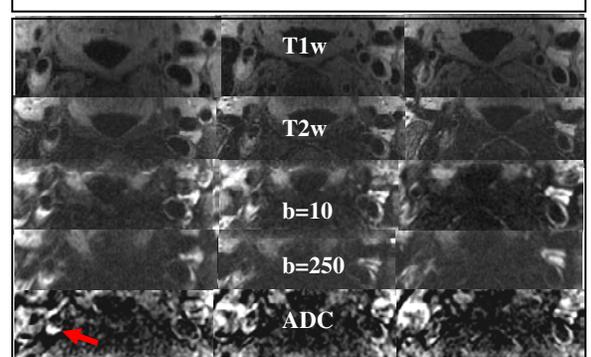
Multiple contrast black blood images including T1, T2, diffusion weighted images and ADC Map DWI ss-rFOV-DWEPI from a patient volunteer
